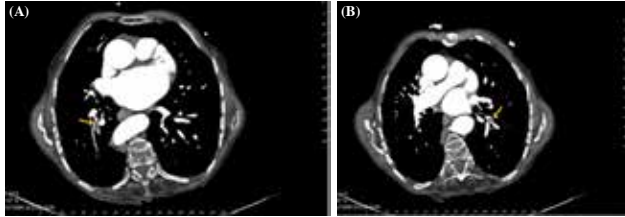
(A) Multi-detector computed tomography image showing subsegmentary embolism at the right pulmonary artery (arrow). (B) Multi-detector computed tomography image showing subsegmentary embolism at the left pulmonary artery (arrow).
